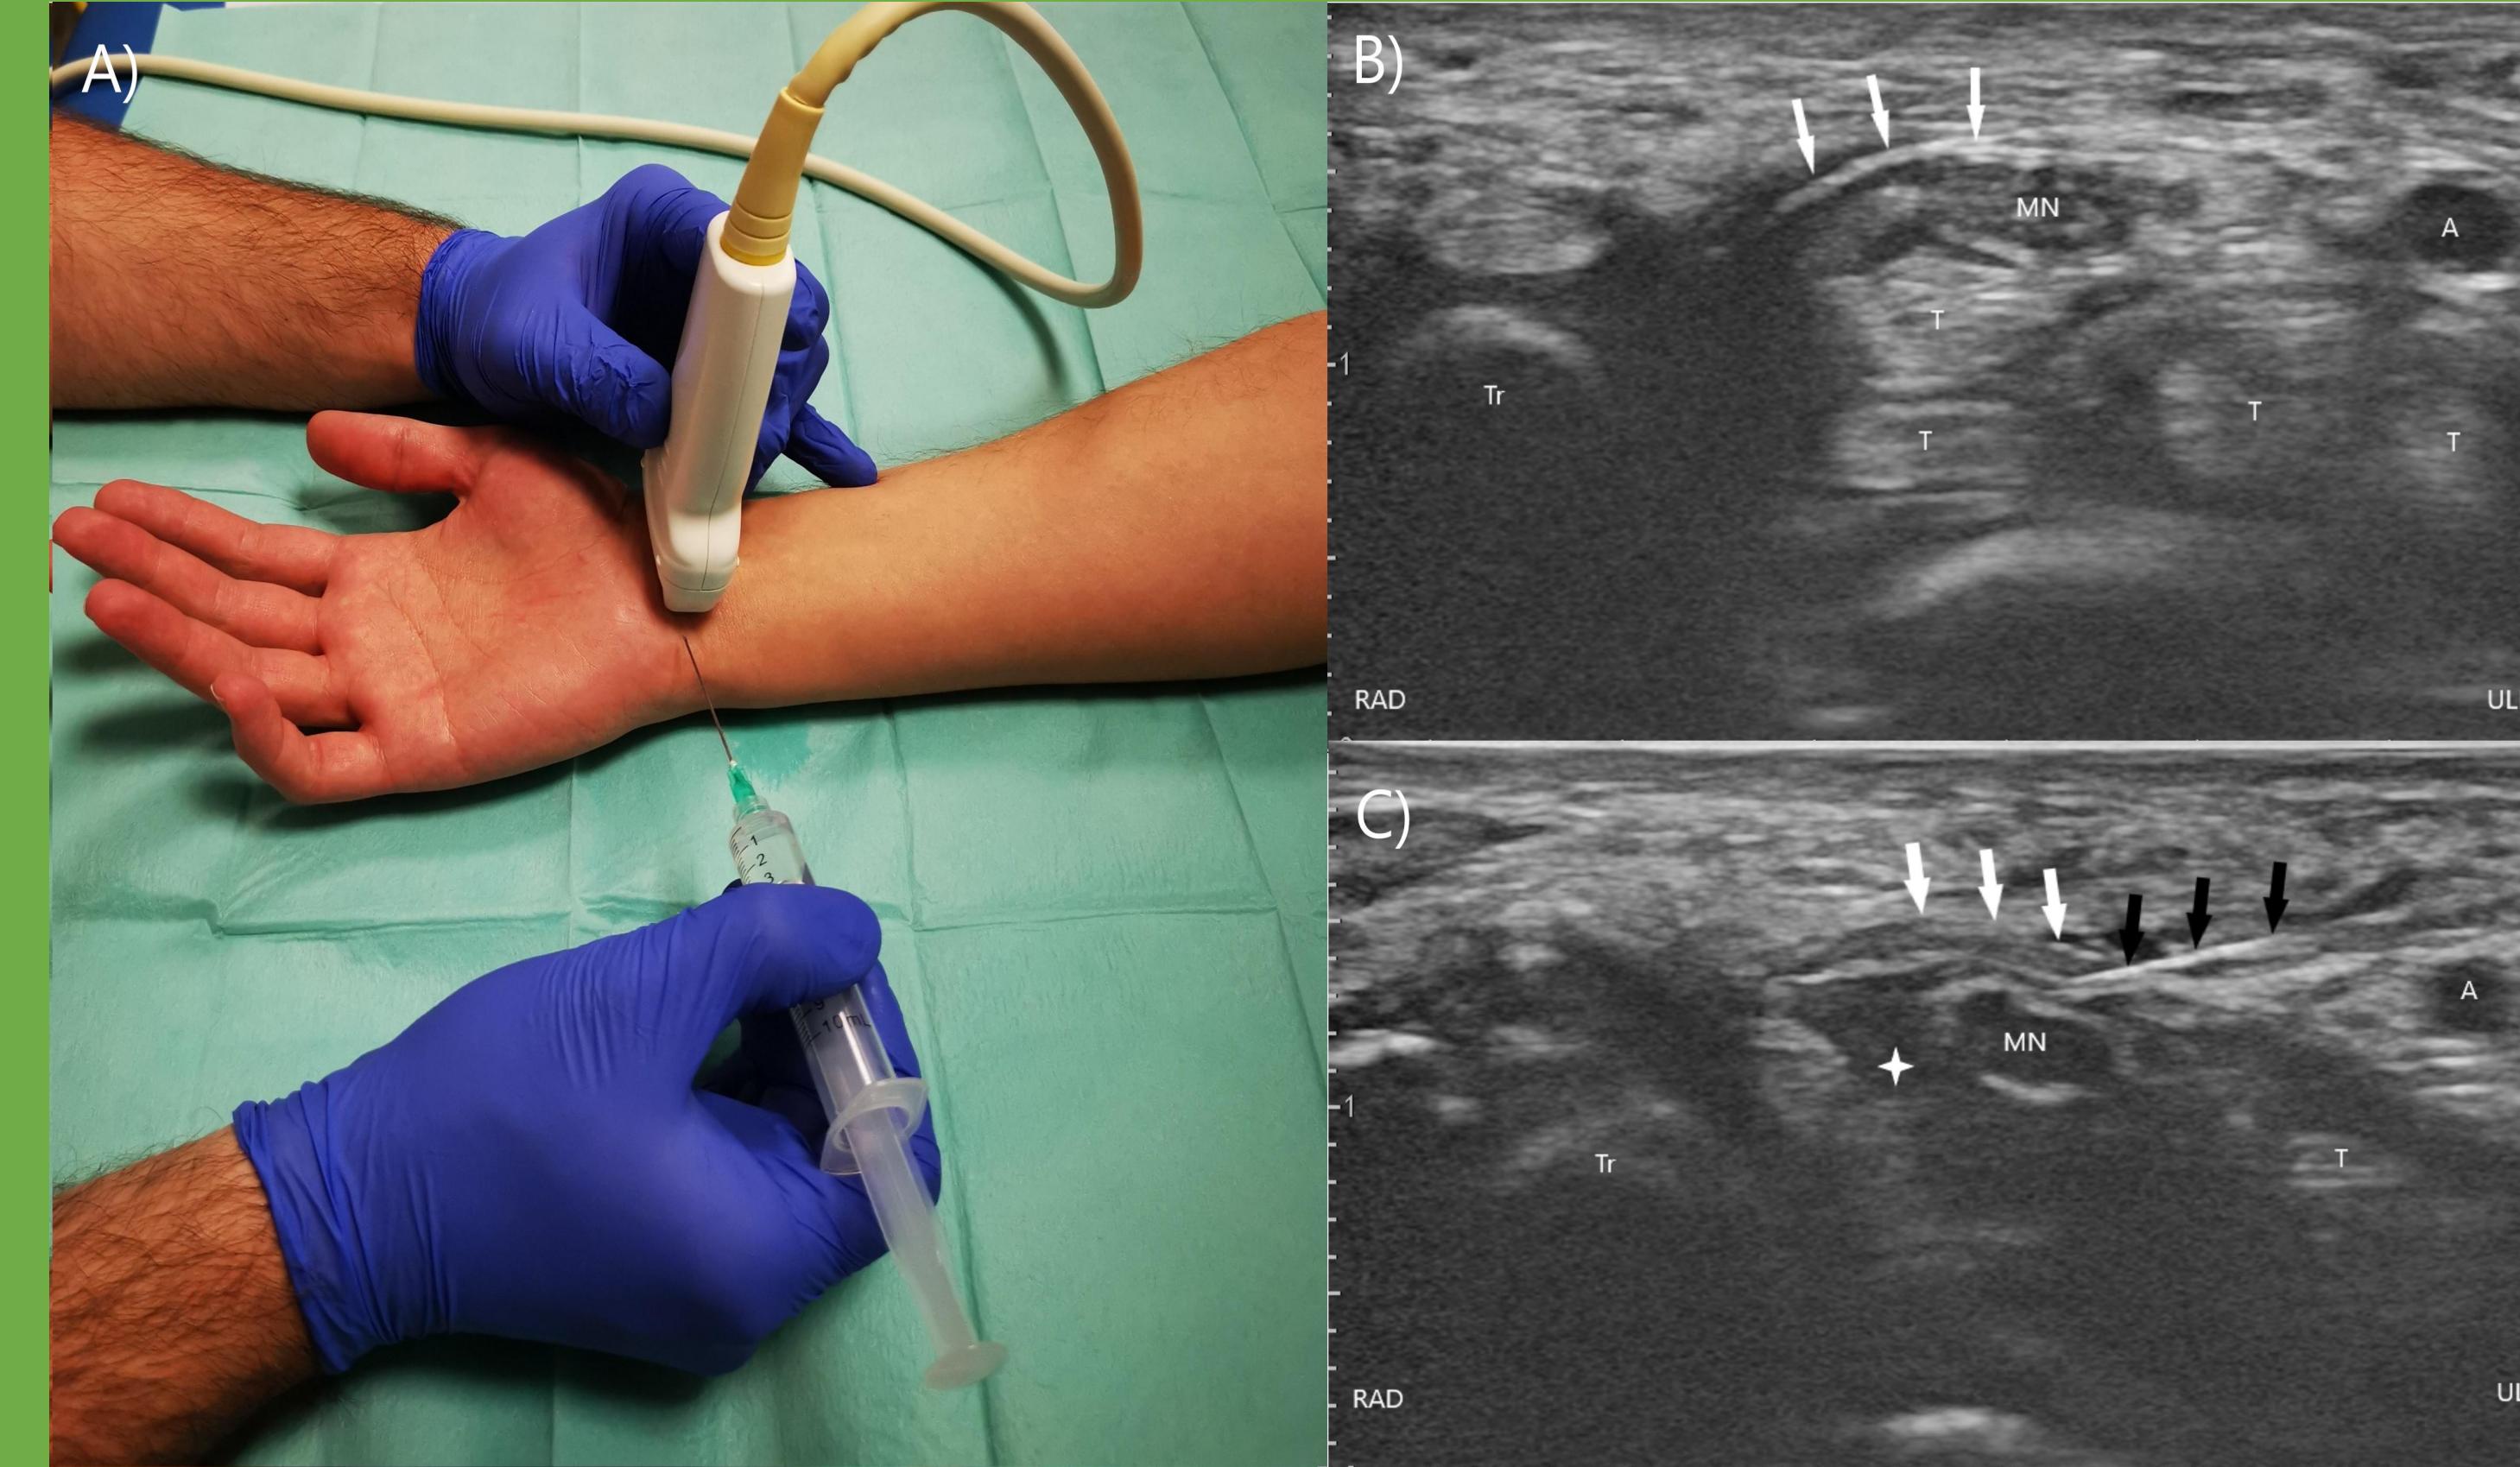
A, B, and C showing the ulnar approach. A; wrist and needle positioning for carpal tunnel injection, B; ultrasound anatomy of the carpal tunnel shown in the short axis, C; penetrating transverse carpal ligament positioning the needle tip above the median nerve Ultrasound of the carpal tunnel after the needle penetrates the transverse carpal ligament. Comparing B and C note the expansion of the perineural space marked with a white cross. (ULN - ulnar, RAD - radial, A - ulnar artery, MN – median nerve, Tr - trapezium, T – flexor tendons, white star – ulnar nerve, white arrows – transverse carpal ligament, black arrows – needle, white cross – perineural injectate); From: Ultrasound-guided carpal tunnel injections. By Tumpaj T, Potocnik Tumpaj V, Albano D, Snoj Z. Radiol Oncol. 2022; 11; 56: 14-22. doi: 10.2478/raon-2022-0004.
